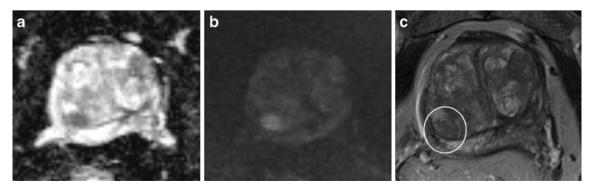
A 70-year-old patient with a small central lesion with increased SI on the high *b*-value images and a negative biopsy. a ADC map with reduced SI; b increased SI on the high *b*-value image ($b=1,000 \text{ s/mm}^2$); c corresponding T2-weighted image of the lesion
